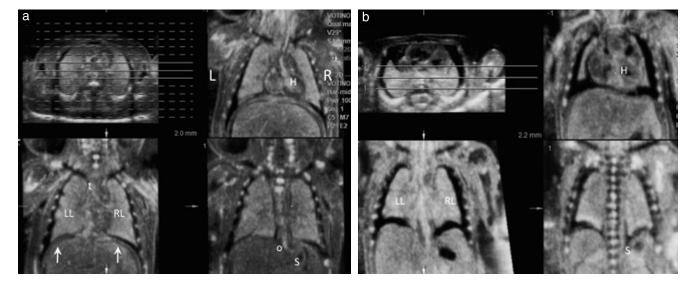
Postmortem ultrasound of fetal thorax and upper part of the abdomen (tomographic ultrasound imaging of coronal plane). Images were obtained using a linear probe (RSP 6-16). (a) Normal fetal thorax in a 14-week fetus terminated for Down syndrome. Cardiac situs is normal and it is easy to identify the stomach (S) on the same side as the heart (H); the diaphragm (arrows) is normal, and the esophagus (o) can be seen entering the stomach; the right (RL) and left (LL) lungs are normally developed and occupy the entire thoracic cavity; also visible is the trachea (t) and its bifurcation. L, left; R, right. (b) A case of hydrothorax and cardiomegaly in a 13-week fetus terminated for trisomy 18 and general anasarca. The increased amount of fluid in the thoracic cavity and cardiomegaly is evident: the fetal heart occupies more than half of the thoracic cavity.
